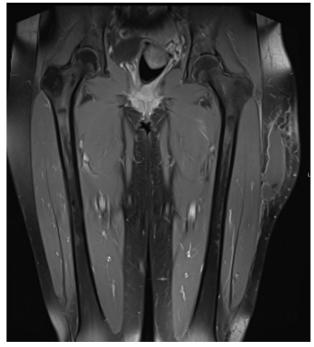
Post-contrast coronal fat saturated T1-W MR image.
